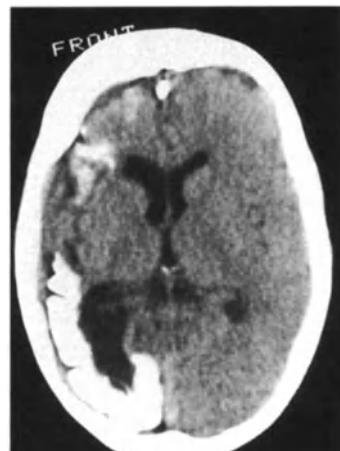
Sturge-Weber syndrome. The CT examination shows heavy cortical calcification, predominantly occipital, with some atrophy.
